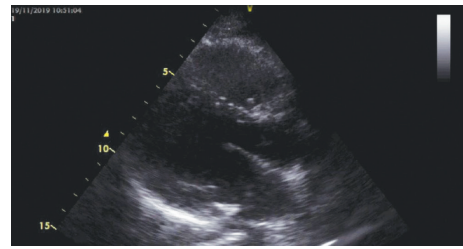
2nd year control echocardiography. In 2nd year control echocardiography, RV wall thickness was normal.
